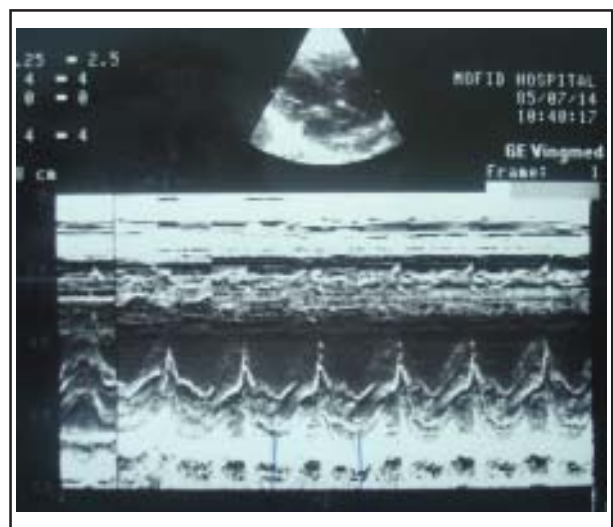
First echocardiograph.
